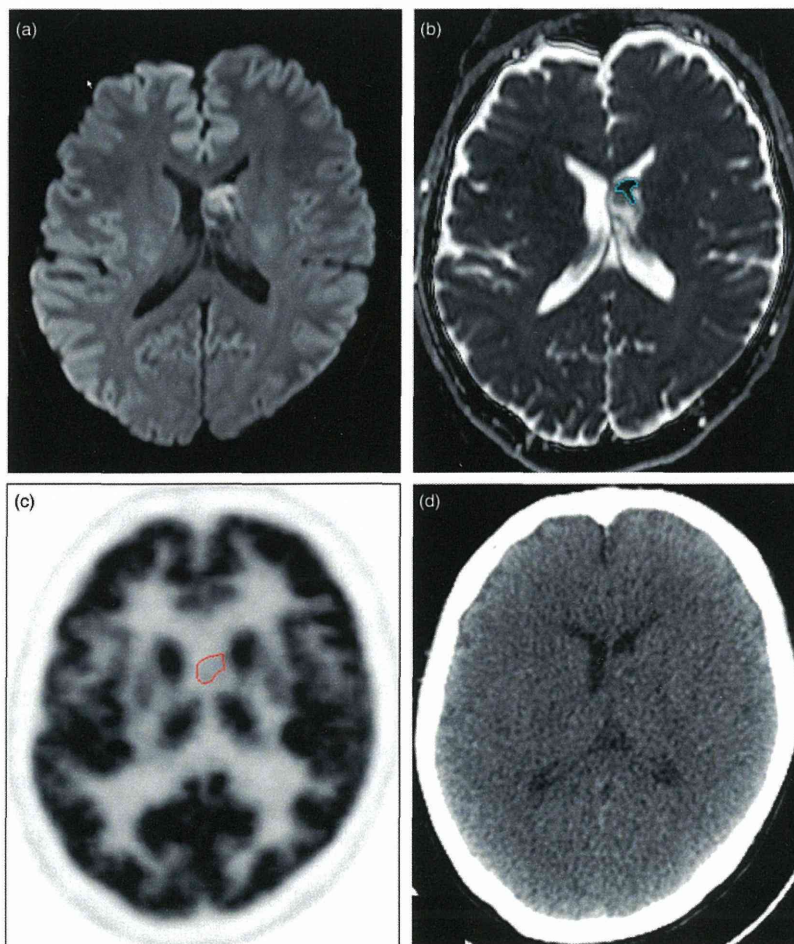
The solid portion of the tumor in the representative case shows high signal on DWI (a) and restricted diffusion on ADC map, where a ROI for ADCmin is drawn (b). A ROI for SUVmax is defined at the same location on FDG-PET (c), referring to simultaneously acquired CT image (d).
